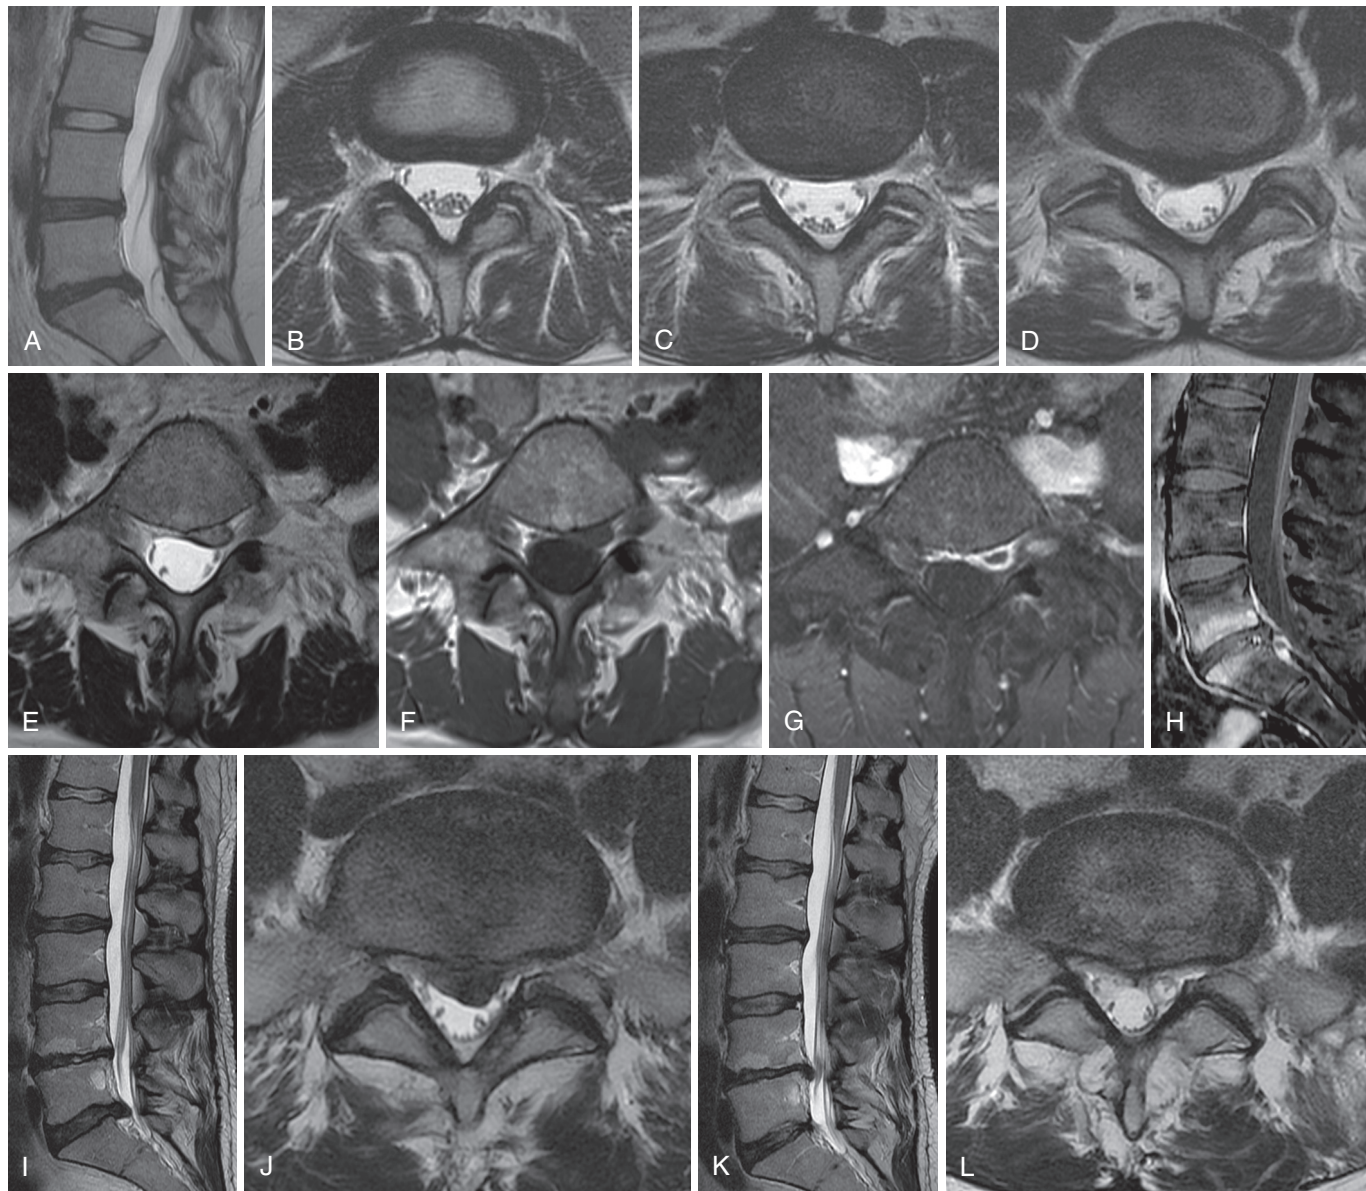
Disk herniations. Sagittal T2 MRI (A) and axial T2 images at L3-4 (B), L4-5 (C), and L5-S1 (D) disks demonstrate a normal L3-4 disk, a central protrusion at L4-5, and a right central extrusion with caudal migration at L5-S1. Axial T2 (E) and T1 (F) MRI images at the S1 end plate level demonstrate a left-sided sequestered disk fragment contacting the thecal sac. Fat-saturated T1 axial image (G) and sagittal image (H) show that much of the apparent disk herniation enhances and is inflammatory reaction about a small disk fragment. Enhancing Modic I change is present. Another patient with left S1 radicular pain due to an L5-S1 disk extrusion (I, J) was treated with a transforaminal epidural steroid injection with resolution of pain. He returned 4 years later with new L5 distribution pain and was reimaged (K, L). Note that the L5-S1 extrusion has completely resolved; (L) is at the identical level as (J) and a new L4-5 extrusion has developed. The natural history of disk extrusion is resolution.
